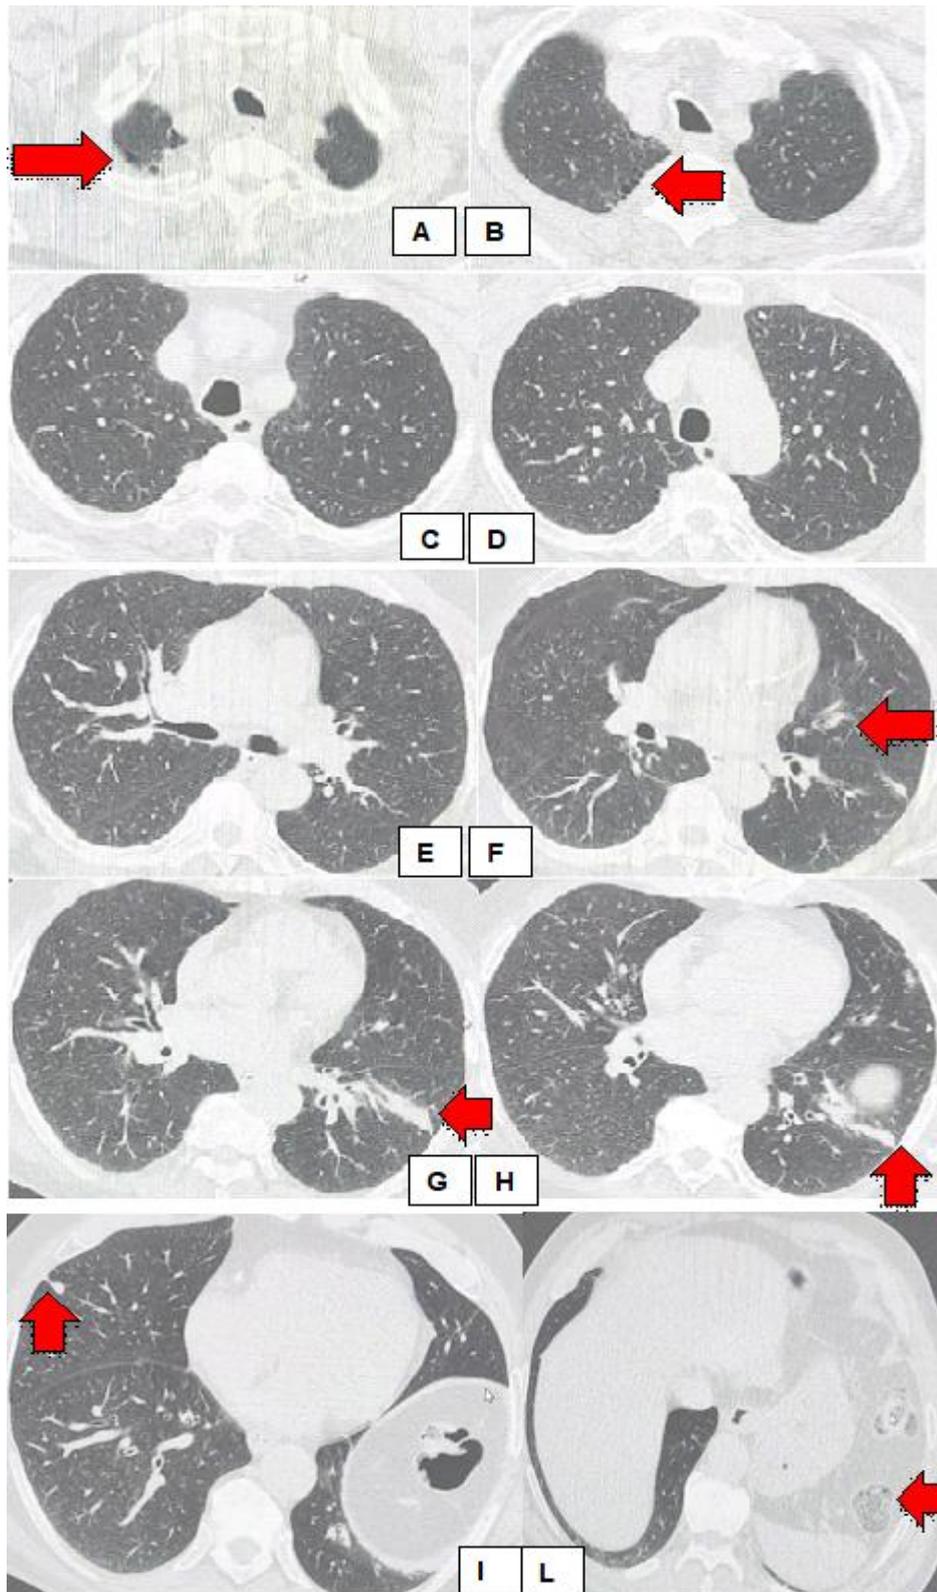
(Panels from A to L): Chest CT-scan in axial sections, shows areas of right apical panlobular emphysema, elevation of left diaphragm, colic loops interposition at the splenic flexure with basal atelectatic phenomena, and the presence of 7mm intraparenchymal lymph node at the lateral segment of the middle lobe as you can see with red arrows.
